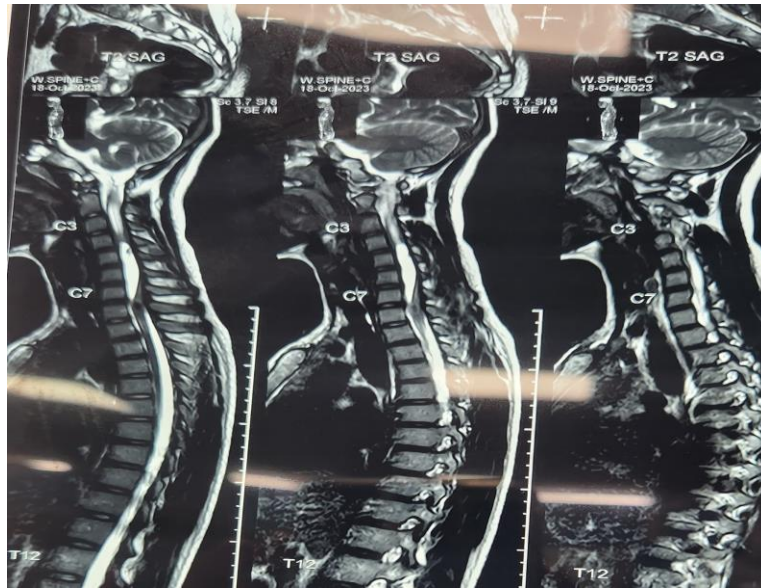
MRI showing anterior soft tissue mass which was cystic at C5 level extending till C7 level with low signal intensity which displaced trachea anteriorly
